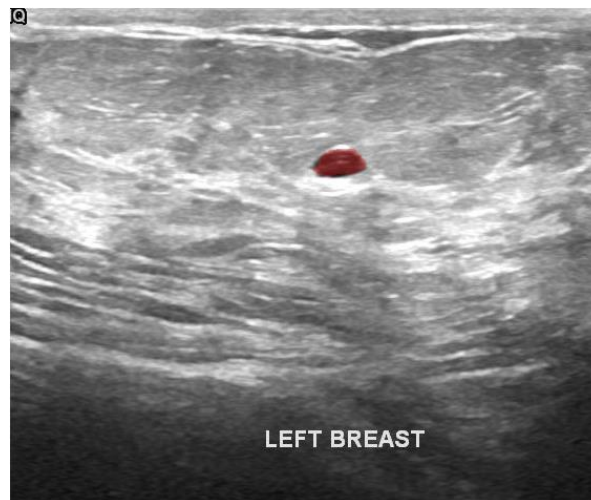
Labeled test ultrasound image by DeepLab v3+ based segmentation
